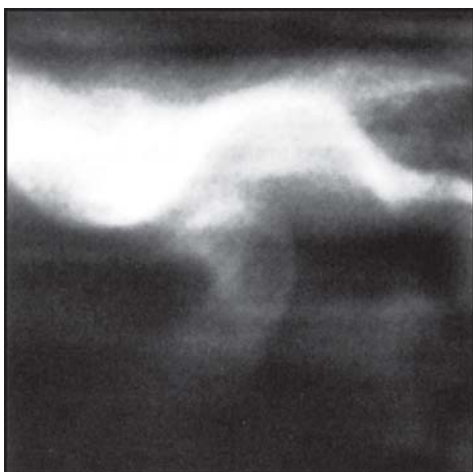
Linear tomogram of the TMJ. Note the horizontal radiopaque streaks in this image. These streaks are called parasite lines, represent the blurred image of objects lying outside the focal plane. They are evident in the image when the long axis of the objects located superficial or deep to the focal plane lie parallel with the path of the X-ray tube and film movement
